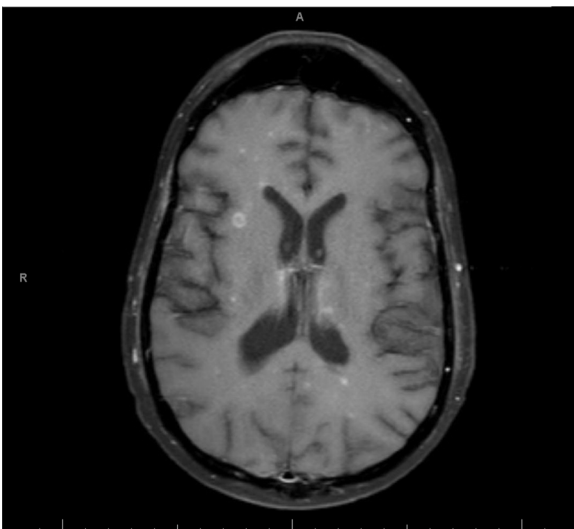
MRI brain on hospital day 36, with punctate enhancing lesions and one notable ring-enhancing lesion (T1 post contrast).
